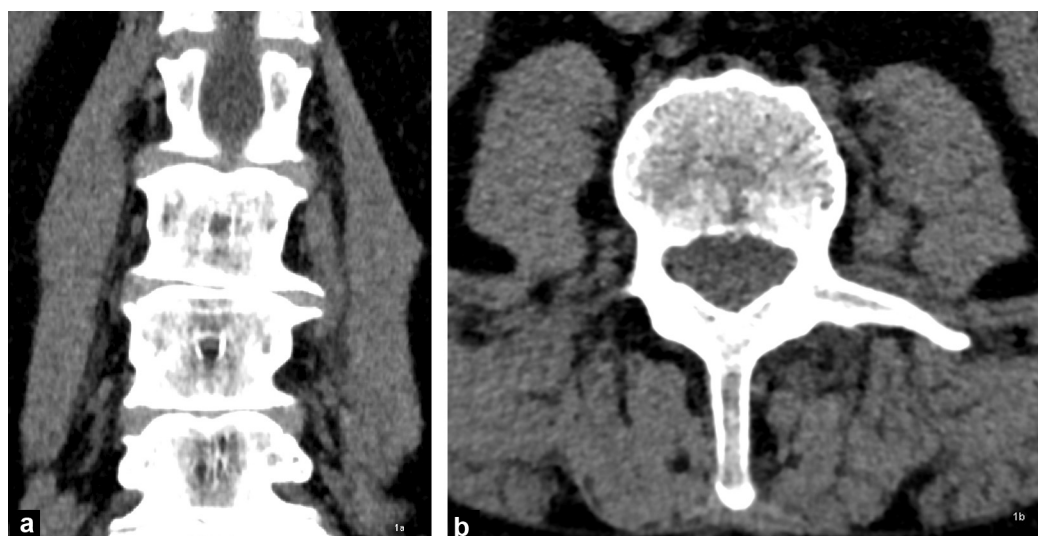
CT scan of the lumbar spine without injection.
